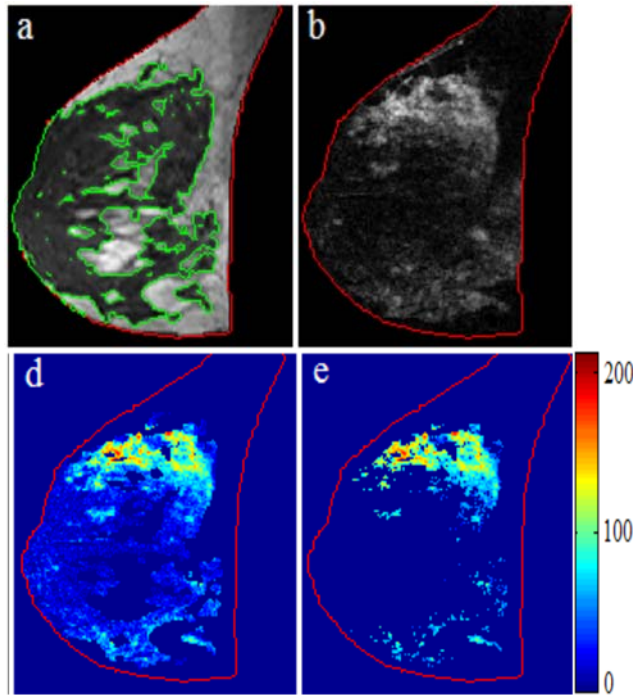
Example of FGT/BPE estimation (a) FGT segmentation (green) on T1 non-fat suppressed MR image, (b) post-contrast T1 fat-suppressed subtraction image (d) color-coded BPE with relative enhancement to pre-contrast DCE-MRI ≥ 0 , and (e) color-coded BPE with relative enhancement $\geq 40\%$.
